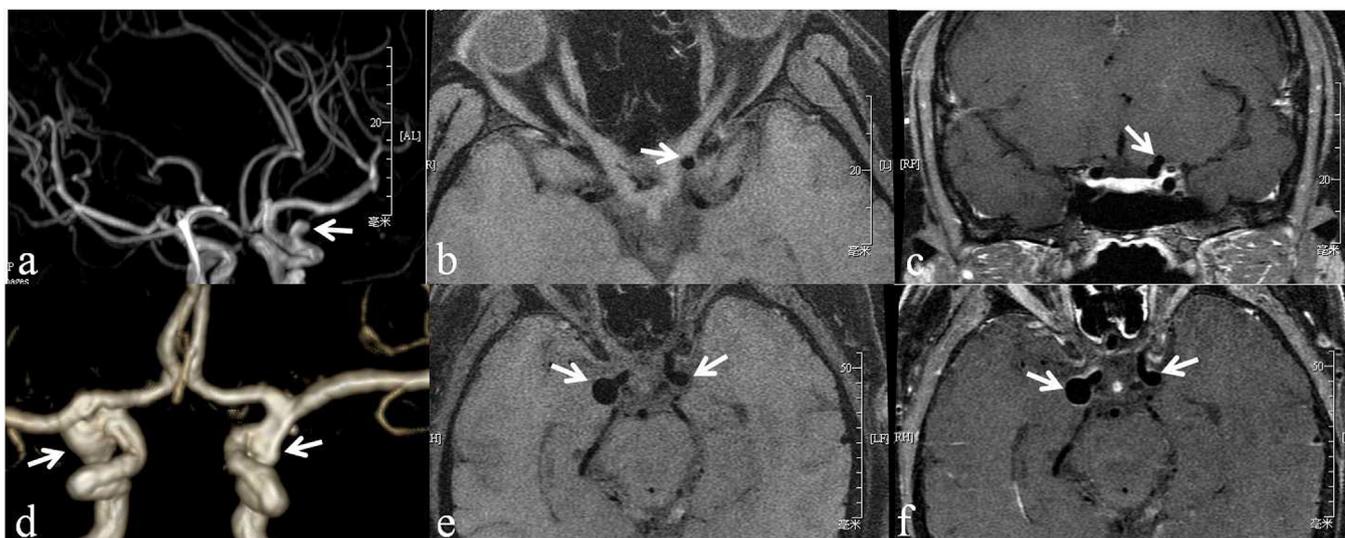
MRA (first column), pre-contrast (second column), and post-contrast T1-weighted (third column) of two patients with and without aneurysmal wall enhancement. (a-c): Female, 50 years old, with a left internal carotid artery terminus unruptured aneurysm and no symptoms. (a): 3D MIP by MRA exhibits the aneurysm (arrow). Post-contrast MRI (c) shows no enhancement of the aneurysmal wall (arrows) compared with the pre-contrast image (b). (d-f): A 64-year-old female patient presented with sentinel headache due to bilateral aneurysms in the posterior communicating artery. (d): 3D VR by MRA exhibits the two aneurysms (arrow). Post-contrast MRI (f) shows entire wall enhancement (arrows) compared with the pre-contrast image (e).
